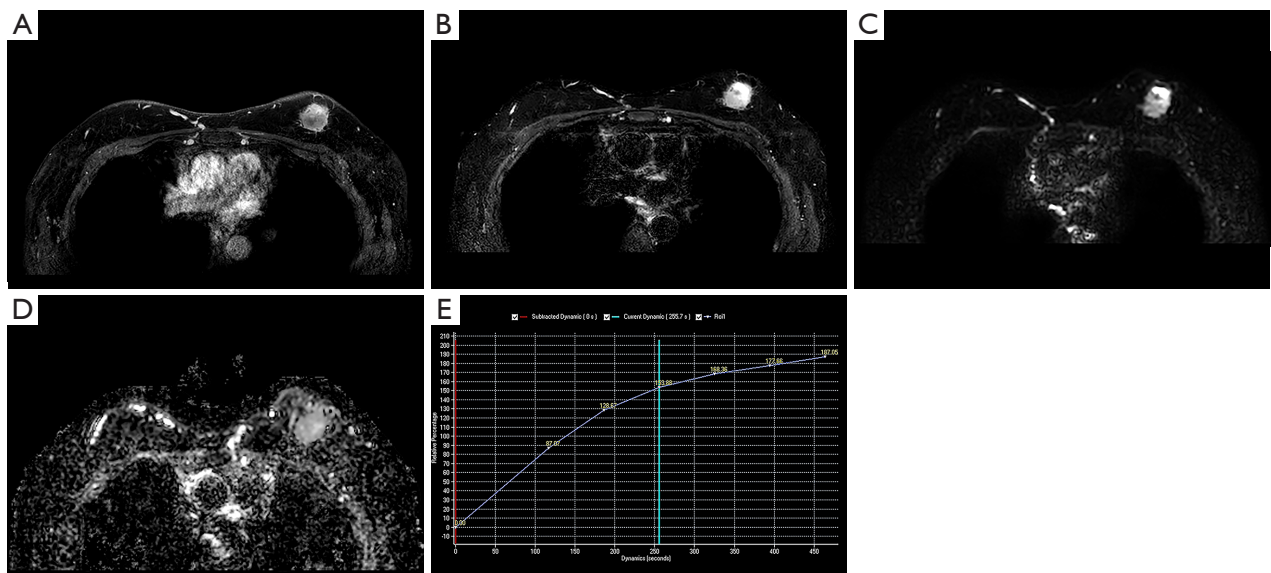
MRI images and dynamic perfusion curve. (A) Transverse T1 fat-suppressed contrast-enhanced scan shows heterogeneous enhancement of the lesion. (B) A T2-weighted fat-suppressed image shows a high signal in the lesion. (C) DWI. (D) Apparent diffusion coefficient map. (E) Dynamic contrast-enhanced perfusion curve. MRI, magnetic resonance imaging; DWI, diffusion-weighted imaging.
